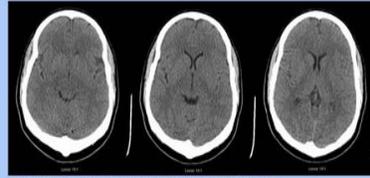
Comparison of CT scans done on admission and approximately 24 hours later, after carotid endarterectomy.
